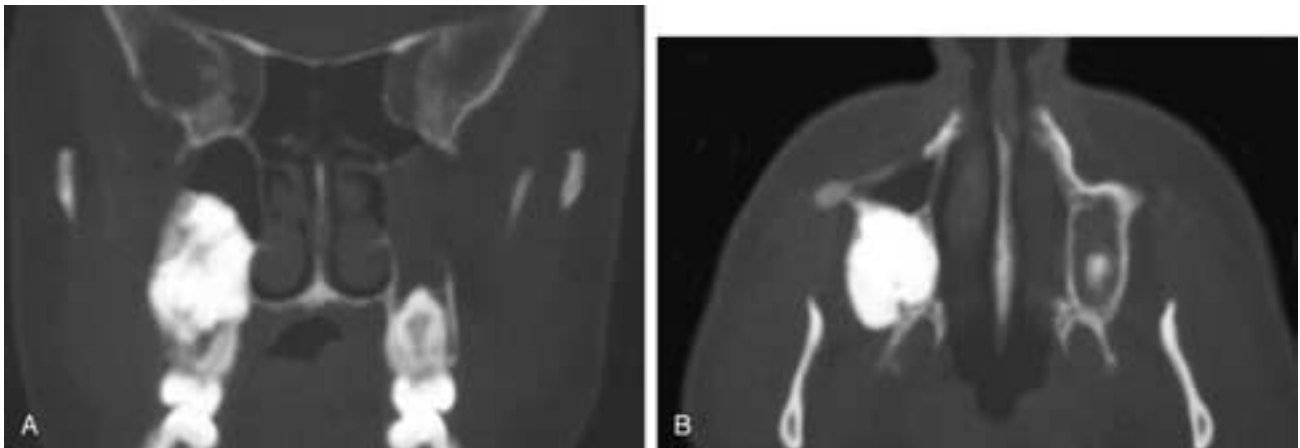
Coronal (A) and axial (B) CT scans show a very dense nodular mass arising from the right maxillary alveolus and extending into the right antrum. This patient had a complex odontoma.
